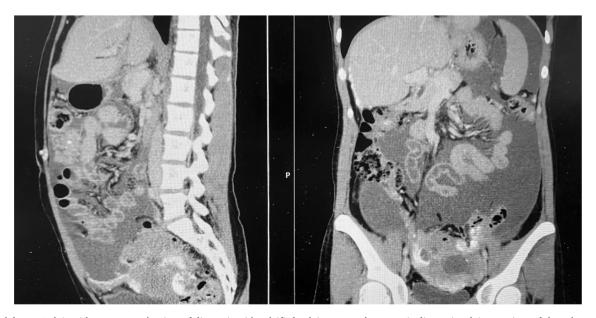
CT abdomen/pelvis with contrast at the time of diagnosis with calcified pelvic mass and metastatic disease involving portions of the colon, small bowel, peritoneum, omentum and anterior abdominal wall.
